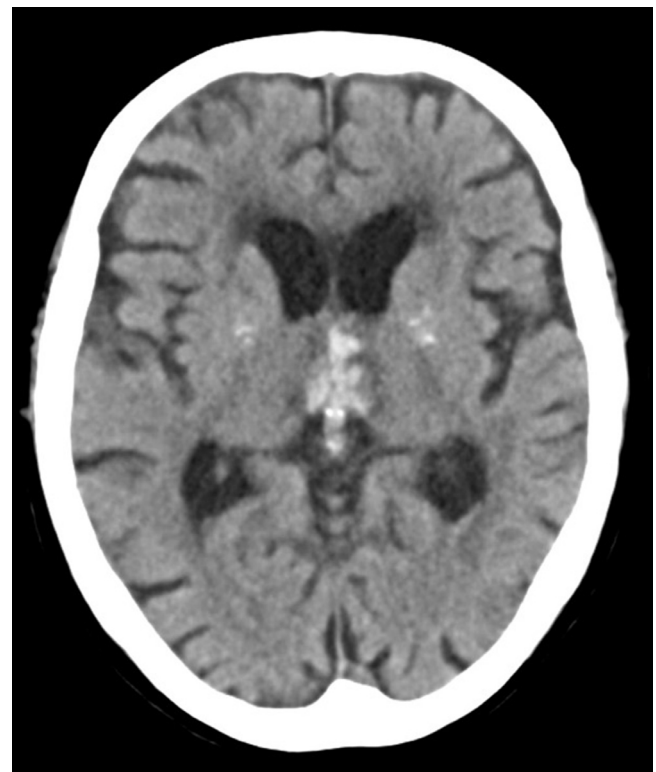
CT on the day of admission. Intracranial hemorrhage from the thalamus is observed on CT (A).
